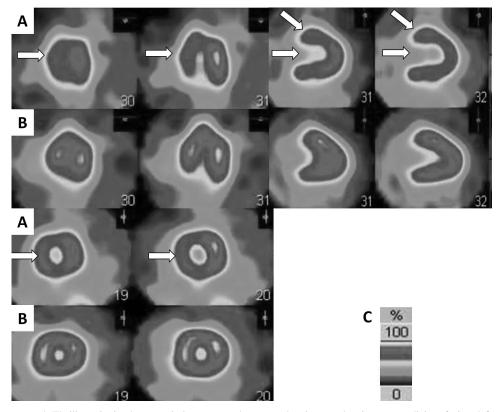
Thallium single photon emission-computed tomography images showing myocardial perfusion defect (white arrows) improved upon dipyridamole (DPM) in a 45-year-old patient with Takayasu arteritis. The images were obtained at rest (A) and after DPM (B). The percentage of perfusion defect is represented by the scale (C).
